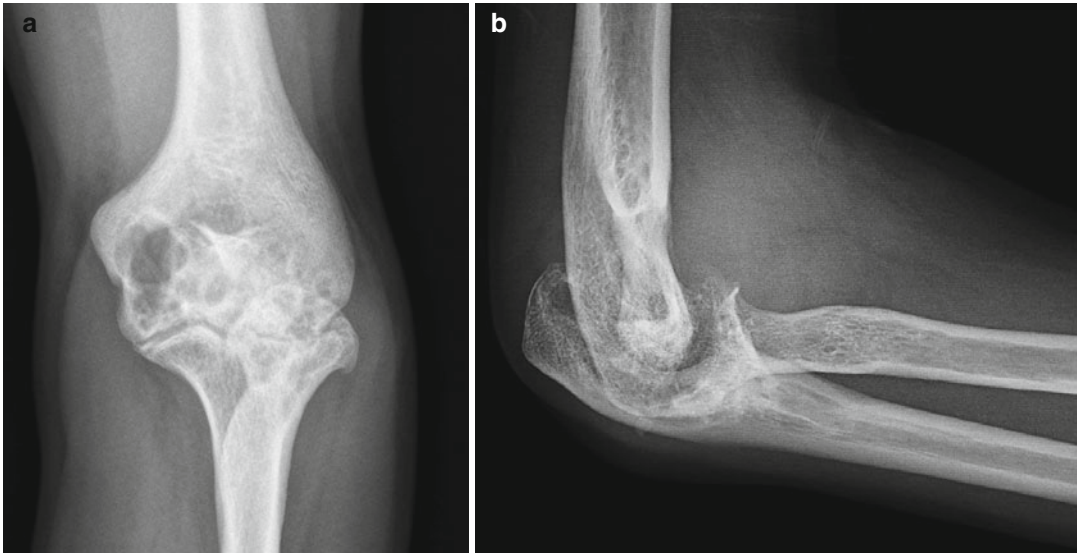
Anteroposterior (a) and lateral (b) elbow radiographs with marked hypertrophy of the radial head that limited forearm pronation. Additionally, some signs of advanced hemophilic arthropathy can be seen
